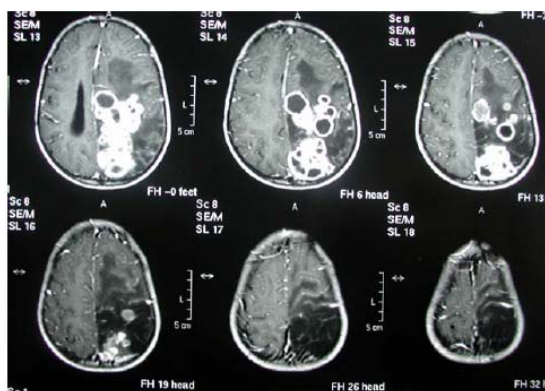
Brain MRI (coronal view) of tuberculous brain abscess of a child with cystic fibrosis
